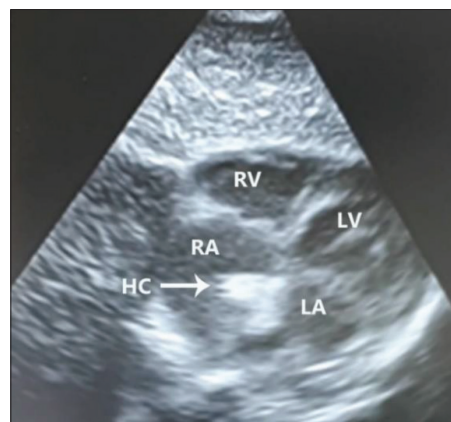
The postoperative heart ultrasound; HC – part of Hickman catheter; LV – left ventricle; RV – right ventricle; LA – left atria; RA – right atria
